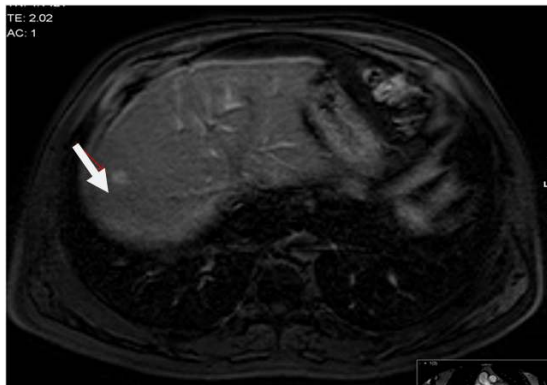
HCC – MRI, T1 SPAIR (fat suppression) Axial contrast-enhanced, arterial phase: The lesion presents contrast uptake in the arterial phase
